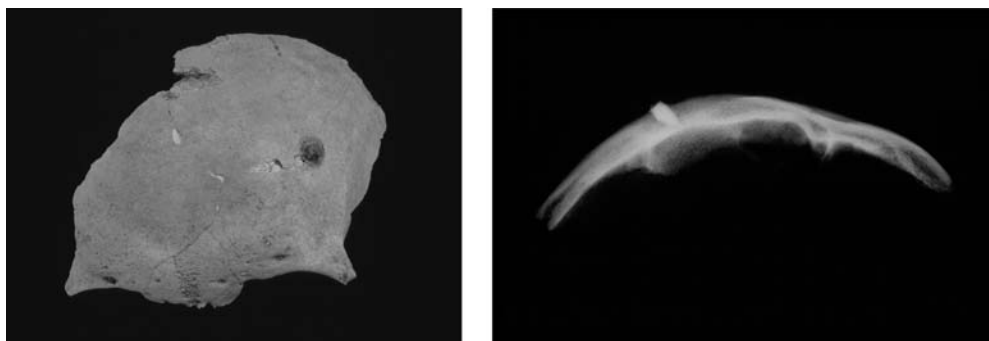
(a) Frontal bone from a burial from Ipswich Blackfriars. There is an iron fragment embedded in the left side. (b) Radiograph (superior view) showing the morphology of the embedded fragment. It appears to be the tip of a projectile point, implement or weapon that has broken off in the bone. It fails to penetrate the full thickness of the frontal bone
